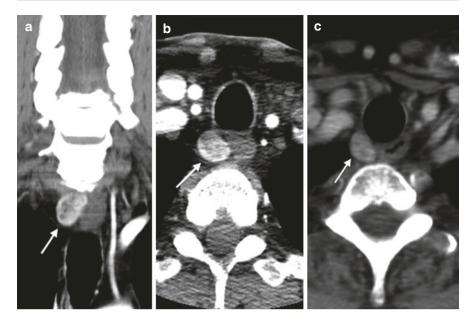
4D-CT: Coronal early phase (a) post-contrast, axial early phase (b) and axial delayed phase (c) post-contrast images showing an early enhancing 1.3-cm nodule in the right tracheoesophageal groove, with modest contrast washout denoting a right inferior PTG in the orthotopic location. Pathology showed a 3-g parathyroid adenoma (arrows)
